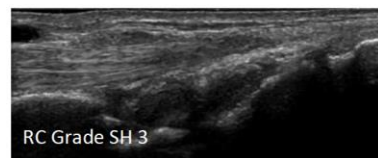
Wrist radio-carpal and intercarpal joint ultrasound grading based on extent of hypoechoic synovial tissue
